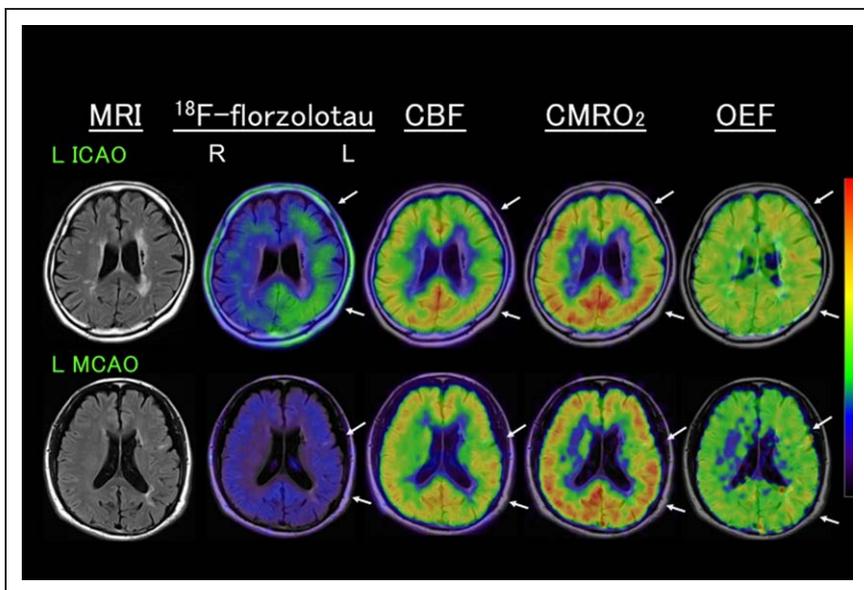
Representative positron emission tomography images. Upper, Increased ¹⁸F-florzolotau standardized uptake value ratio (SUVR; 0.94, ipsilateral/contralateral, 1.12), with decreased cerebral blood flow (CBF) and increased oxygen extraction fraction (OEF; 50.5%), despite a reduction in cerebral metabolic rate of oxygen (CMRO₂), in a patient with left (L) internal carotid artery occlusion (ICAO) (fetal type). Note a relatively lower ¹⁸F-florzolotau uptake in the anterior middle cerebral artery (MCA) region with a relatively lower CMRO₂. Lower row: a low ¹⁸F-florzolotau SUVR (0.77, ipsilateral/contralateral, 1.02) in a patient with LMCA occlusion (O) with mild decreases in both CBF and CMRO₂ and normal OEF (46.0%). Arrows indicate the affected regions. Both patients were negative for amyloid positron emission tomography (PET).⁷ MRI indicates magnetic resonance imaging. R indicates right.
